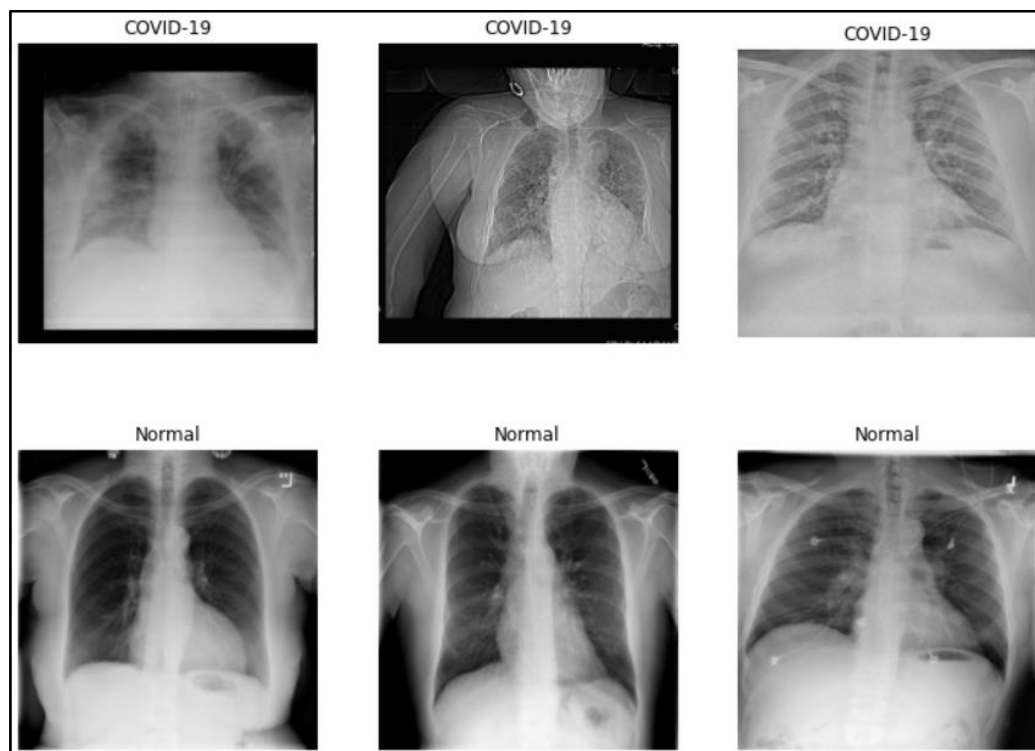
Sample x-ray images of COVID-19 and Normal Classes.
